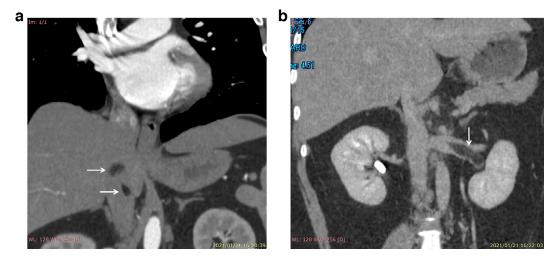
Contrast-enhanced computed tomography images obtained before referral to our hospital. Coronal images (a, b) show well-circumscribed homogeneous fat-attenuating masses in the IVC and left renal vein (white arrows).
